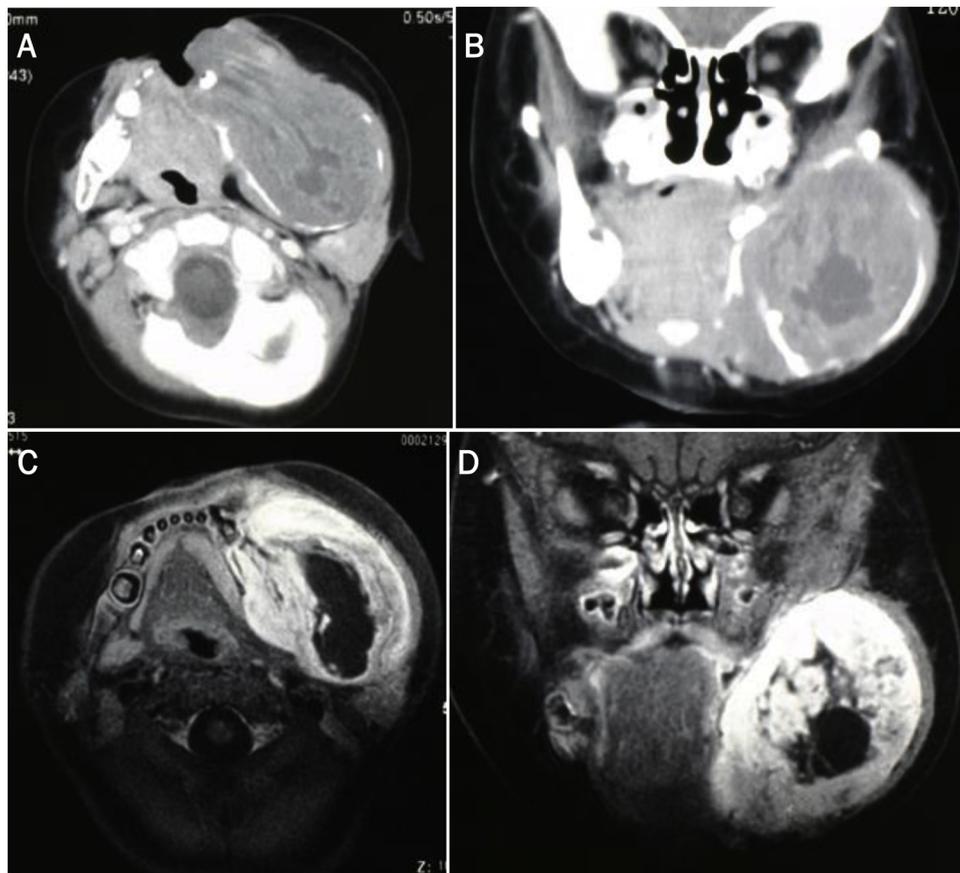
A,B: Pretreatment CT. C,D: Pretreatment MRI. The tumor grew to 90 × 83 × 55 mm around the lower jawbone.
